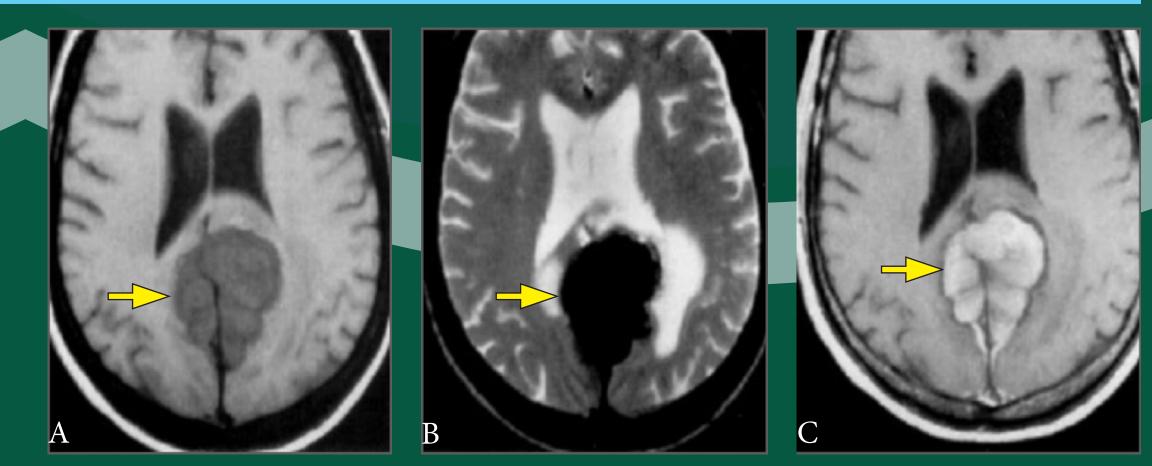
MRI of the brain. (A-C) axial projections demonstrating space occupying
